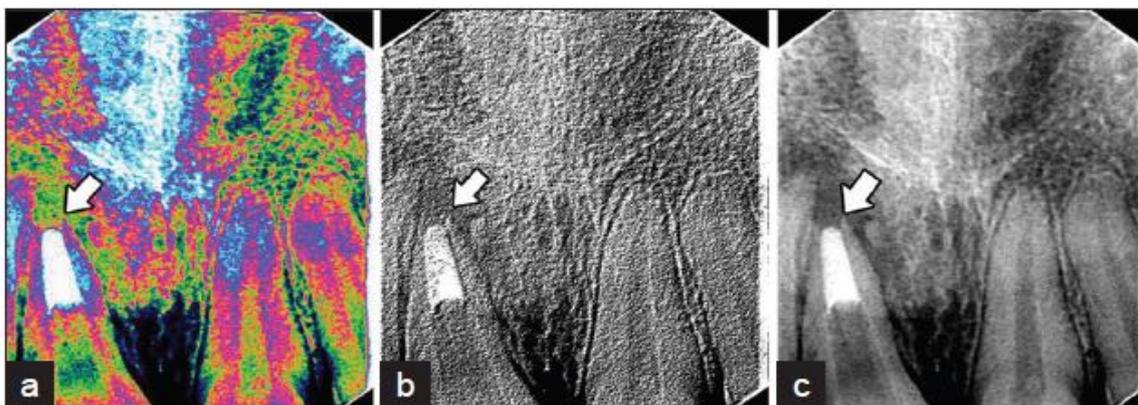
Various RVG images (a) Pseudo color RVG image shows obturation in the apical third of the root canal and resorption of the root apex. (b) 3D RVG image of a periapical lesion and root canal obturation. (c) Normal RVG image of a periapical lesion and root canal obturation.^[1]
